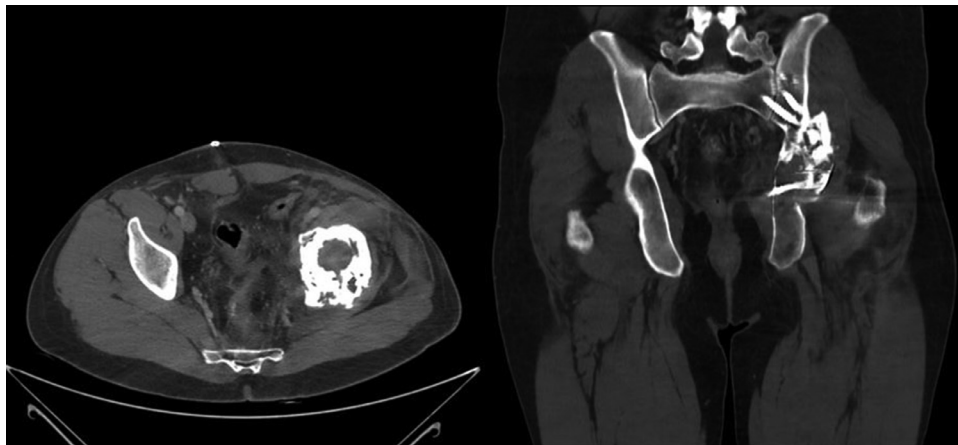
CT scan post-excision of the disease recurrence with implant retention.
